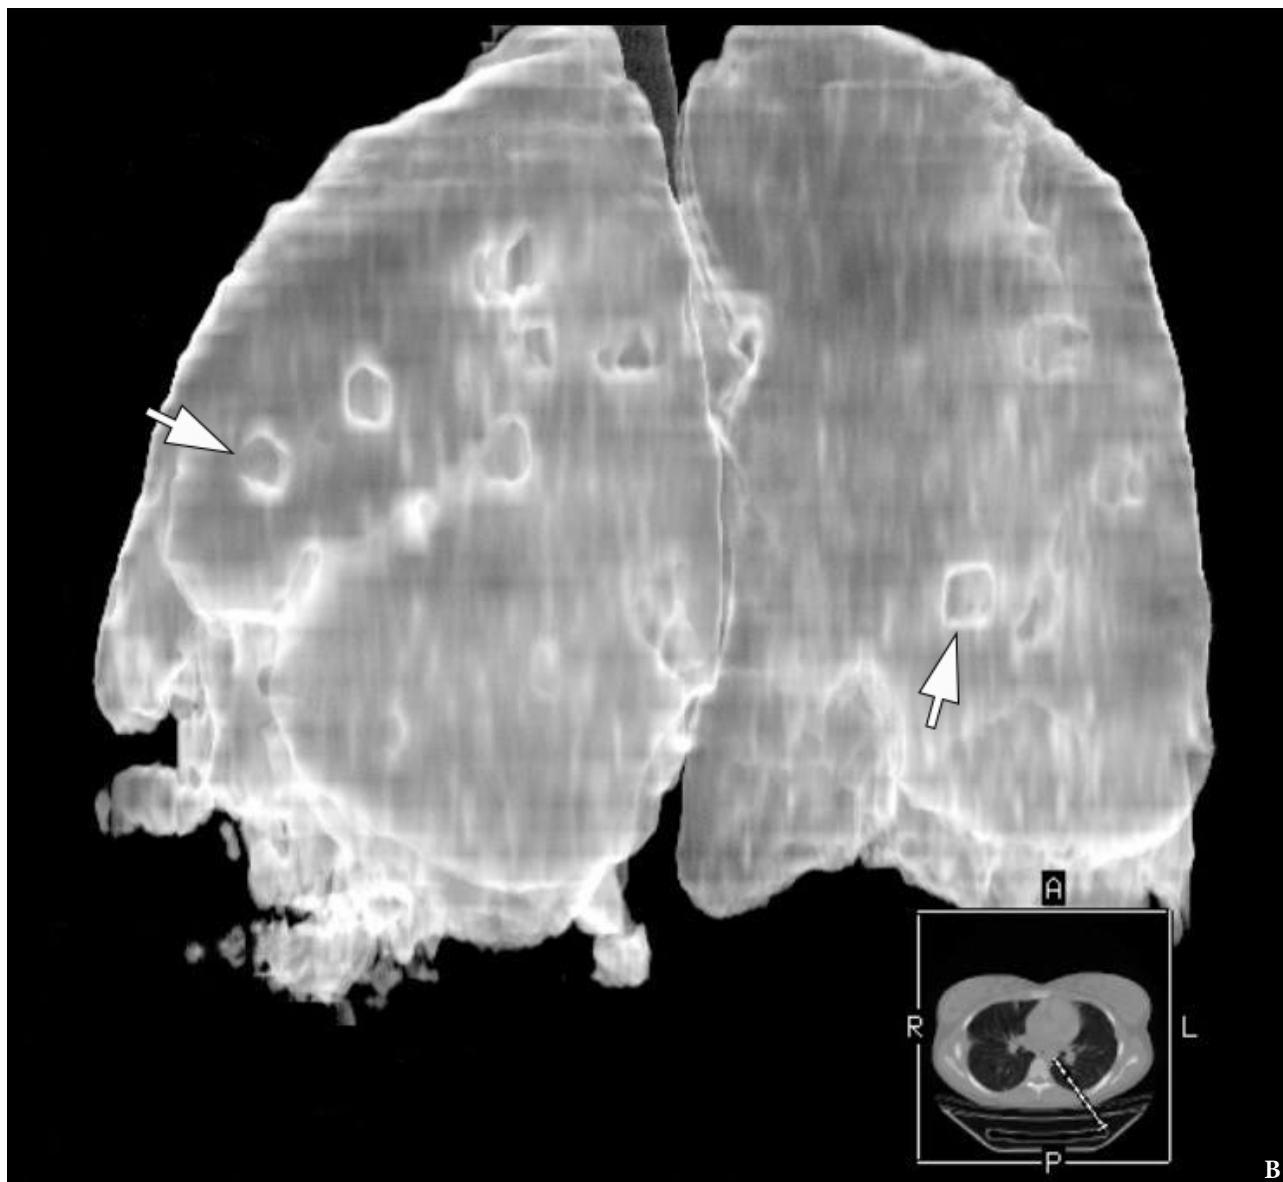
(continued). A three-dimensional multi-slice computed tomography images (A, posterior view; B, latero-posterior view; C, anterior view) of the lungs at day 18 of treatment of the severe lower lip infection. The infection process complicated by lip necrosis, septic bilateral necrotizing pneumonia, and pleurisy (pleuritis). Notes multiple areas of pulmonary tissue necrotizing cavities (*arrows*) due to septic bilateral necrotizing pneumonia. A, anterior; P, posterior; R, right; L, left. Magnification 1.1x. Printed with permission and copyrights retained by I.I.F. (Figure 9 continued on next page.)
